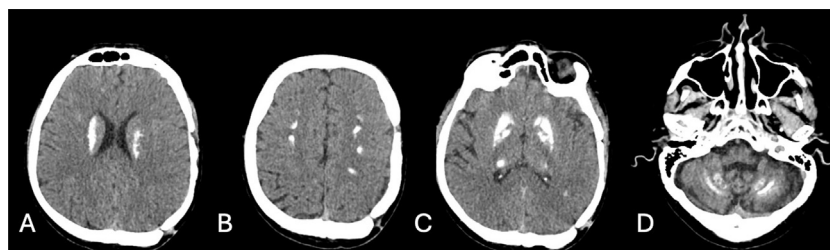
Axial noncontrast computed tomography imaging of the brain demonstrated extensive, bilateral, symmetrical, irregular, amorphous calcifications located within the bilateral corona radiata (A), bilateral centrum semiovale (B), bilateral gangliocapsular region (C), bilateral thalamus (C), and bilateral dentate nucleus (D).
